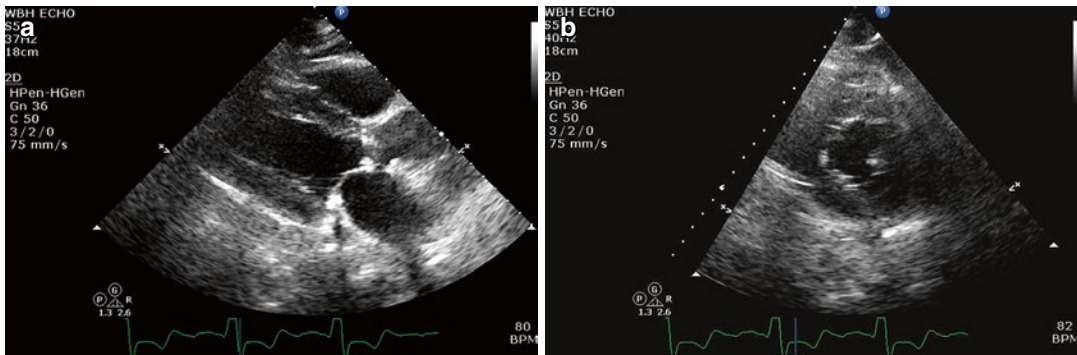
Parasternal long (a) and parasternal short-axis (a) views of the left ventricle (LV) demonstrating increased wall thickness and normal chamber size. The aortic valve is calcified. The left atrium (LA) appears mildly dilated
